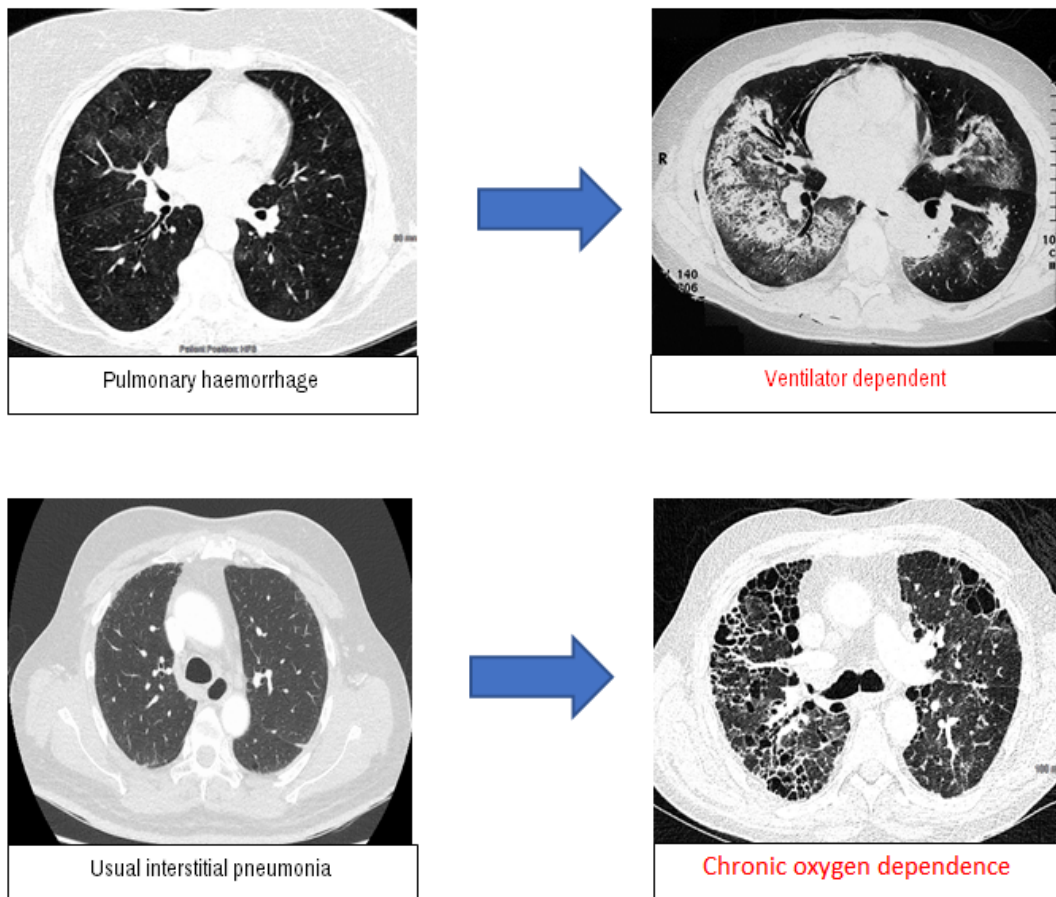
CT images showing progression of lung disease in AAV.
